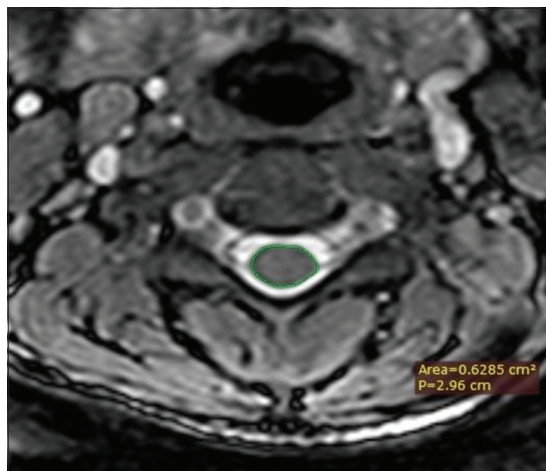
Axial T2-weighted magnetic resonance image, at C2 level showing method of measurement of cervical cord cross-sectional area.
